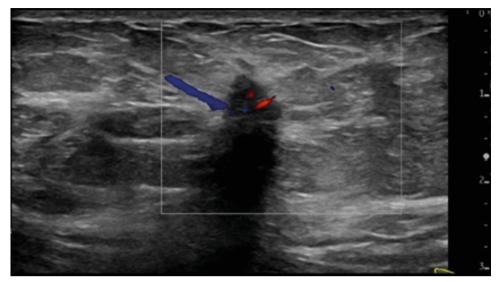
Color flow ultrasound image. There is an irregular vascular mass with acoustic shadowing.
